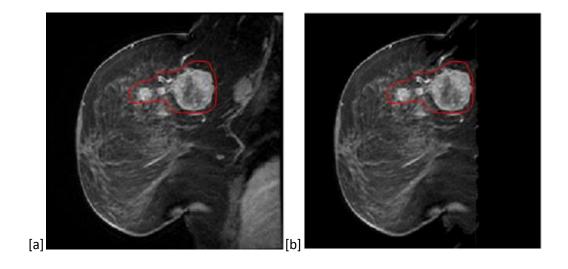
MR image of breast with known malignancy (highlighted area) [a] original image and [b] segmented image after elimination of areas posterior to and including the chest wall. Noise areas inferior to the nipple have also been removed to improve processing time
